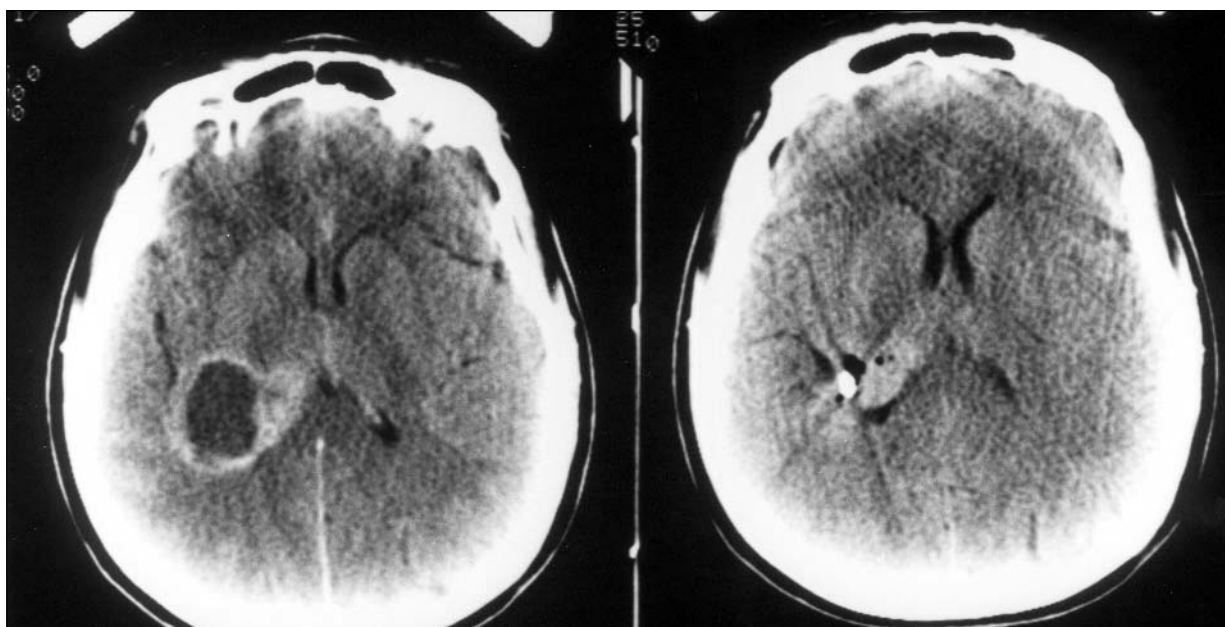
Axial contrast enhanced CT scan showing a large cystic tumor (left). The Axial CT scan of the same patient immediately after stereotactic aspiration and reservoir placement showing complete cyst evacuation (right).
